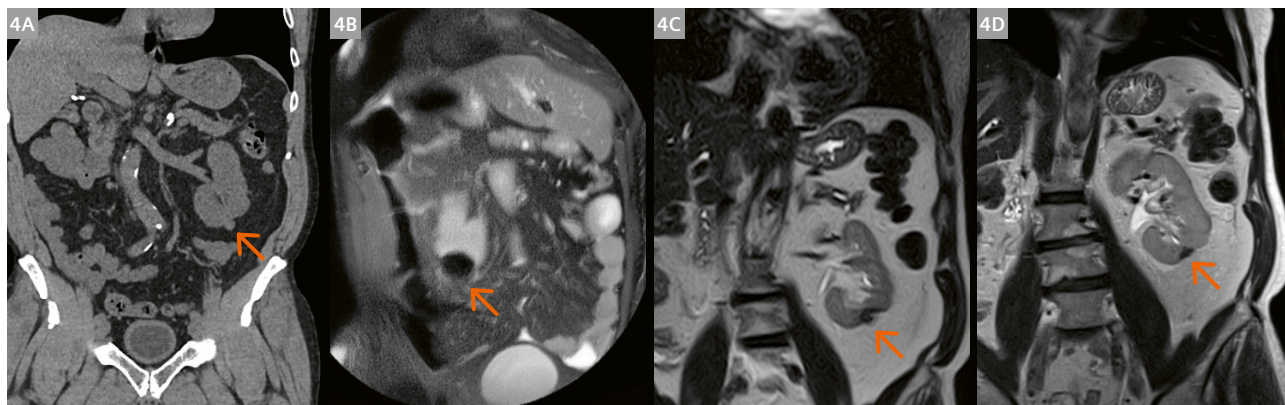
Image-guided percutaneous thermal ablation with MRI is enhanced with more precise lesion visualization and the ability to monitor ablation temperature: either heat or cold. While US, and to a lesser extent CT, can provide some real-time ablation monitoring, MRI has superior soft tissue contrast and, together with MR thermometry, offers a unique feature for monitoring the ablation procedure.
